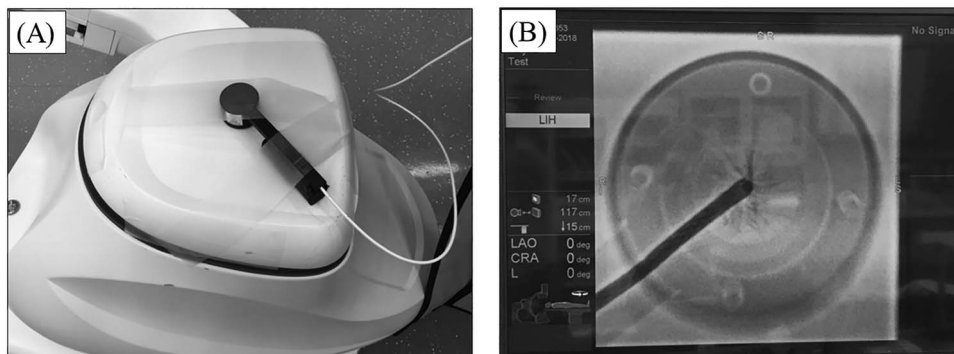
The ionization chamber used to measure the air kerma rate. The 1-cm³ ionization chamber was attached to the X-ray tube assembly (A). The chamber was carefully positioned at the center of the radiation field of view using fluoroscopic imaging (B).
